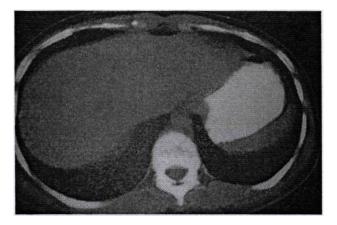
Computed tomography. Patient I., 11 years old. Hemoperitoneum
